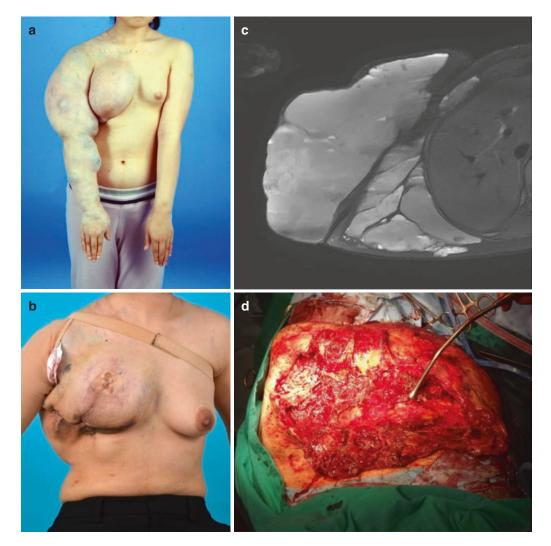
CC: mass on right chest and arm. Dx: Venous malformation. (a) preop picture. (b) postop picture. (c) preop MRI. (d) op finding
